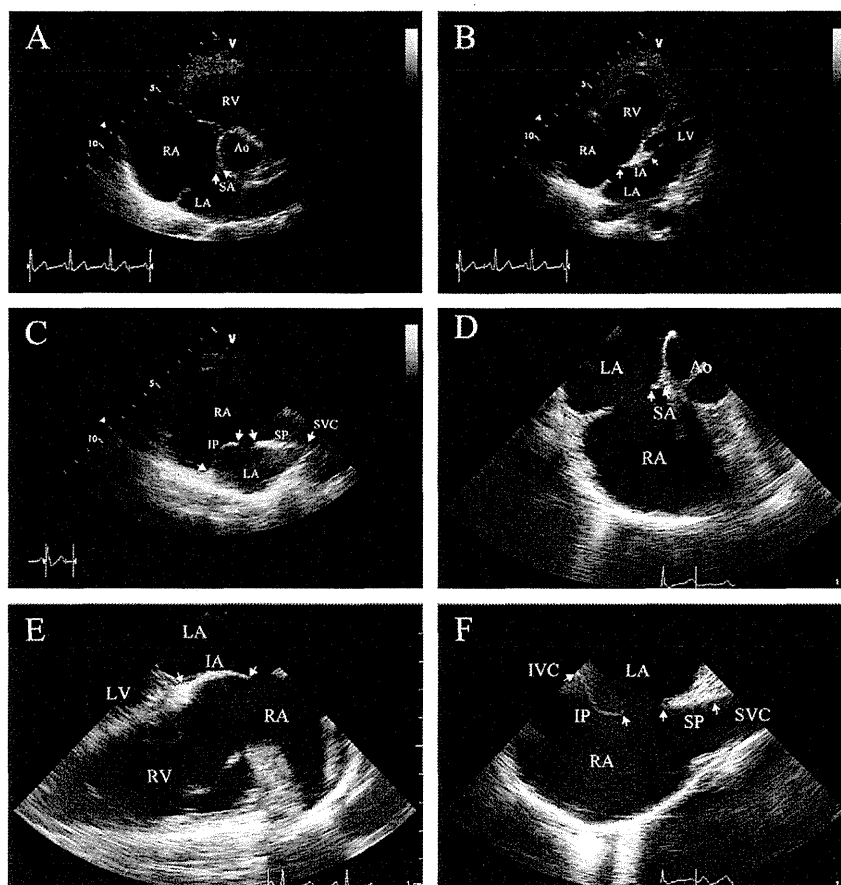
Measurement of maximal ASD diameter and the surrounding rims on 2D TTE and 2D TEE. The surrounding rim is measured from mark (*white arrow*) to mark (*white arrow*). (A) Left parasternal short-axis view, (B) left parasternal four-chamber view, (C) right parasternal longitudinal view, (D) short-axis transesophageal echocardiographic view (0° – 30°), (E) four-chamber transesophageal echocardiographic view (135°), (F) biatrial transesophageal echocardiographic view (90°). The surrounding rims are measured at end-systole (*white arrow*). Ao, Aorta; IA, inferoanterior rim; IP, inferoposterior rim; IVC, inferior vena cava; LA, left atrium; LV, left ventricle; RA, right atrium; RV, right ventricle; SA, superoanterior rim; SP, superoposterior rim; SVC, superior vena cava.
